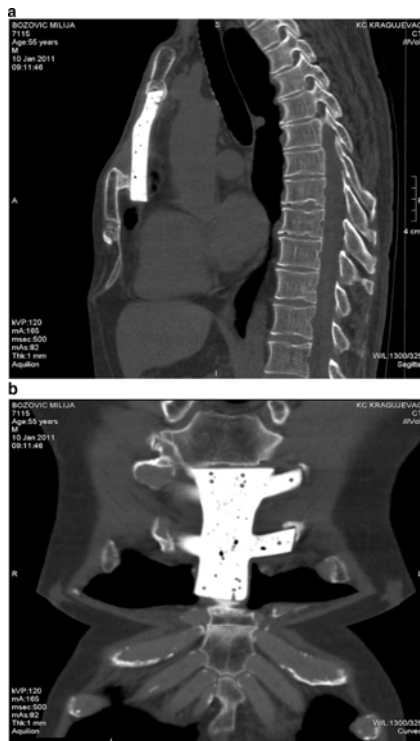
a and b Control CT of the thorax 1 year after implementation (CT, computed tomography)
